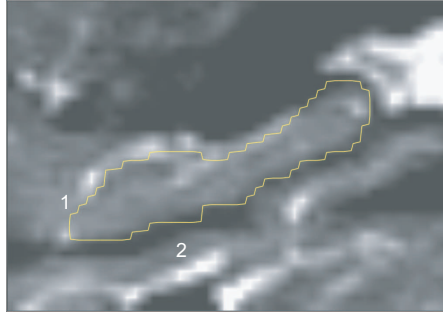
A Half Fourier Acquisition Single Shot Turbo Spin Echo (HASTE) image of a human hippocampus (sagittal view) acquired with a 1.5 MRI unit. The yellow boundary marks the border of an expert segmentation. Note that the amygdala (1) and parahippocampal gyrus (2) have a similar intensity distribution.
